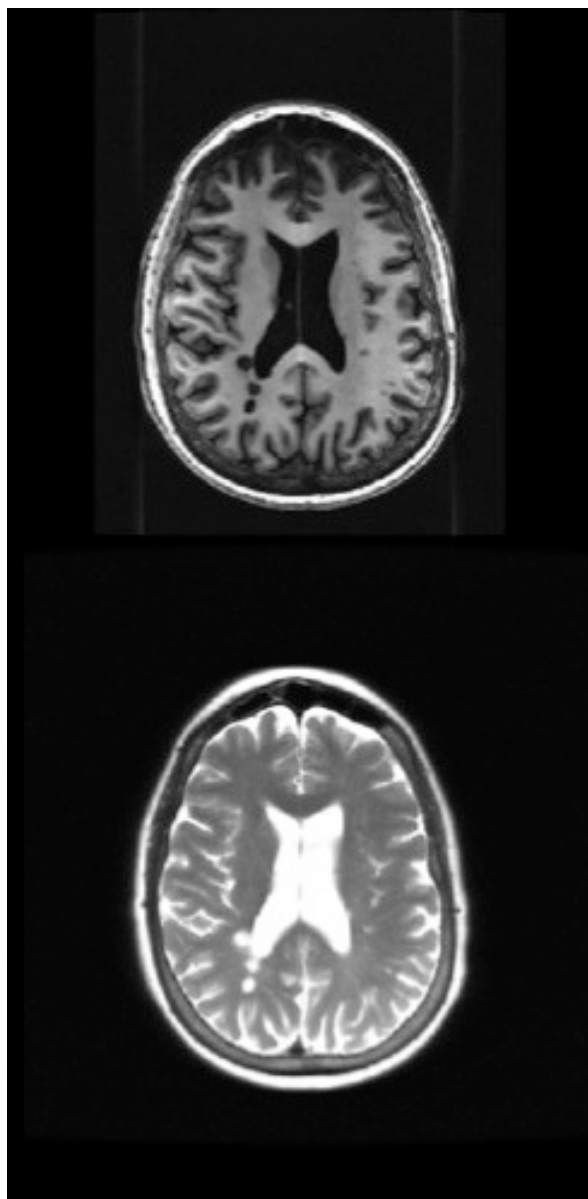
Brain of individual with Multiple Sclerosis with lesions visualized using T1-weighted (top) and T2 weighted (bottom) magnetic resonance imaging.
